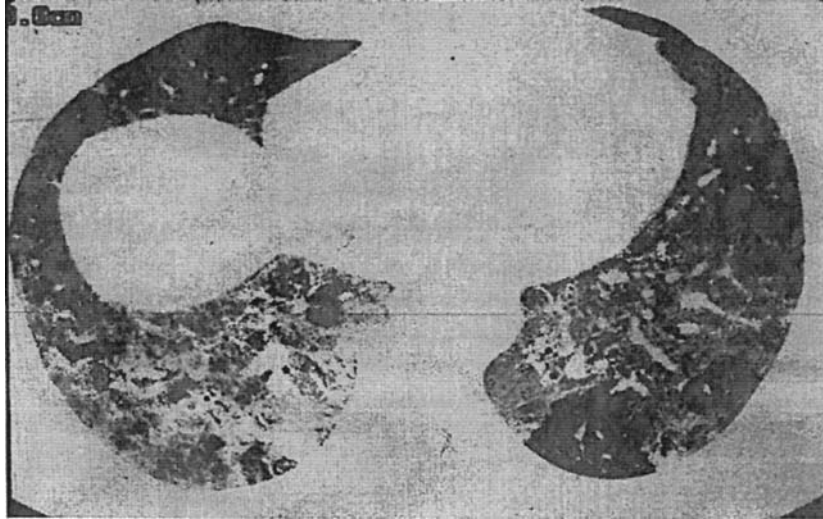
Acute hypersensitivity pneumonia. HRCT scan (lower lobes) demonstrates diffuse ground glass attenuation and bronchial dilatation. No honeycomb change.
